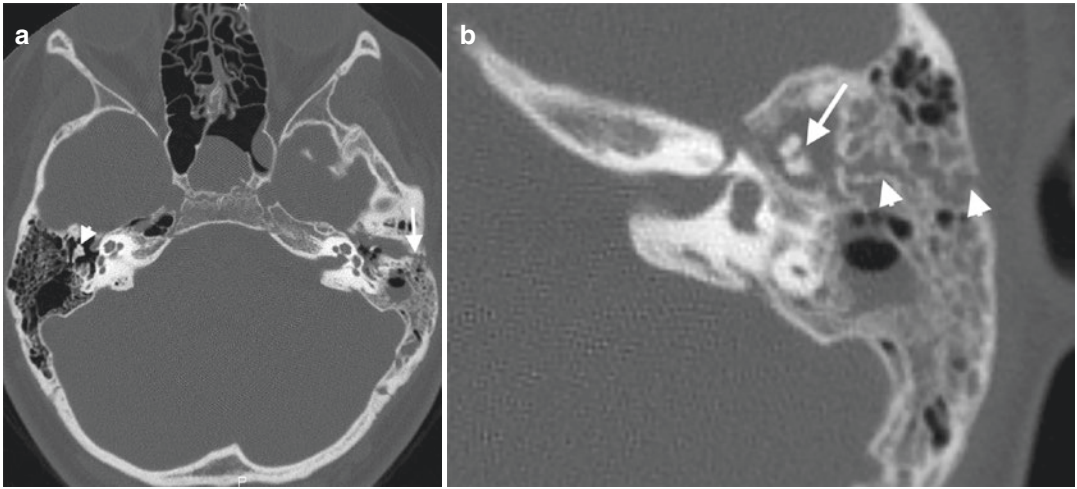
Incudomalleolar subluxation in a 17-year-old man after MVA. (a) Axial CT image shows a longitudinal fracture (arrow) in the left temporal bone. Normal ice cream cone appearance (arrowhead) is shown on the right
